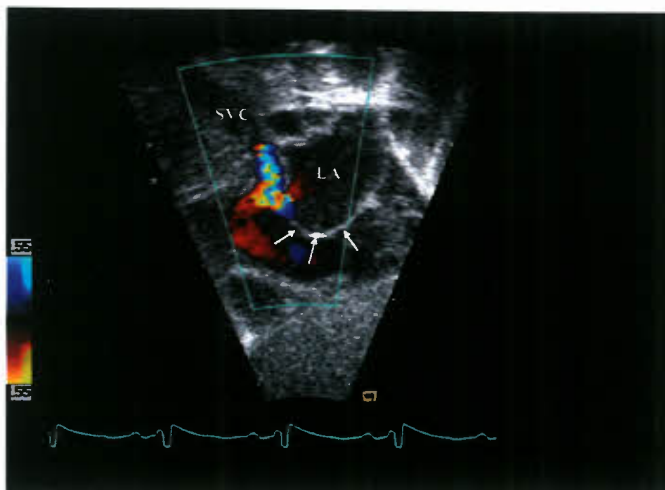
Subcostal sagittal view in a patient with HLHS. The atrial septum is aneurysmal (*arrows*), bowing into the RA. Color Doppler imaging identifies the superiorly positioned atrial shunt with the jet directed into the superior vena cava (SVC). Aliasing of the color Doppler flow signal across the atrial septum is consistent with a restrictive defect and can result in left atrial hypertension. LA, left atrium.
